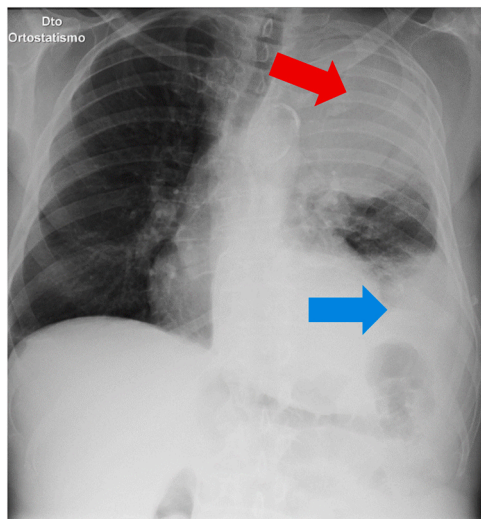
Chest radiography showing a mass-like opacity in the upper third of the left lung (red arrow) and a moderate volume pleural effusion (blue arrow); mediastinal shift is also observed.
